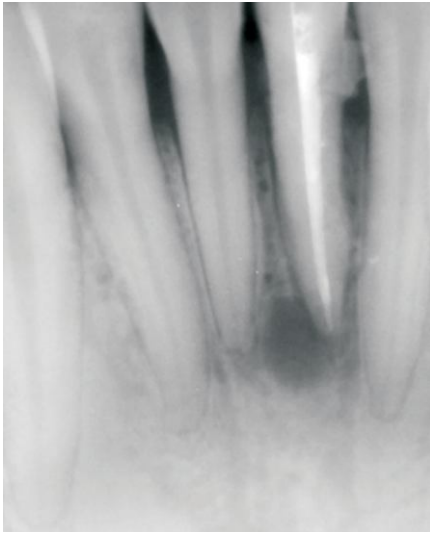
a. Radiograph - review after 3months
